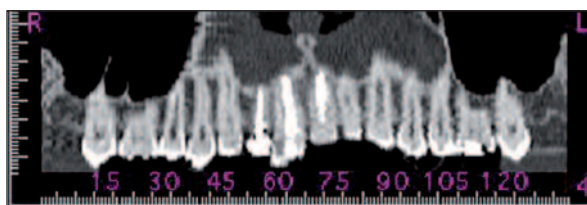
The image obtained from CT was spirally scanned with 1 mm of cross-section after five years. (see for colored form <http://dishekimligi.turkiyeklinikleri.com/>)
